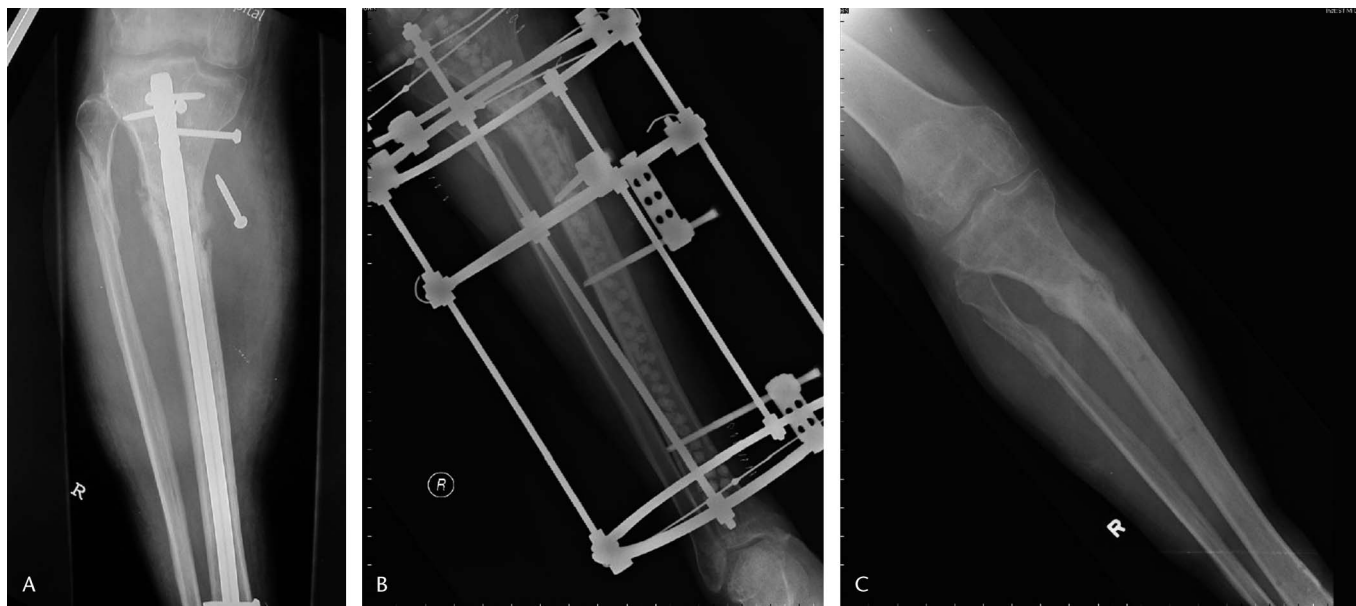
(A) Anteroposterior radiograph of infected an proximal tibial nonunion in a 47-year-old male physician with intramedullary sepsis, active drainage, loss of fixation, and significant varus deformity. (B) Anteroposterior radiograph after hardware removal, radical débridement, irrigation, insertion of antibiotic-impregnated calcium sulfate pellets, and the application of a ring external fixator. (C) Anteroposterior radiograph 1 year postoperatively after fixator removal demonstrating solid bony union and anatomic alignment. Clinically and radiographically, the patient was infection-free.
